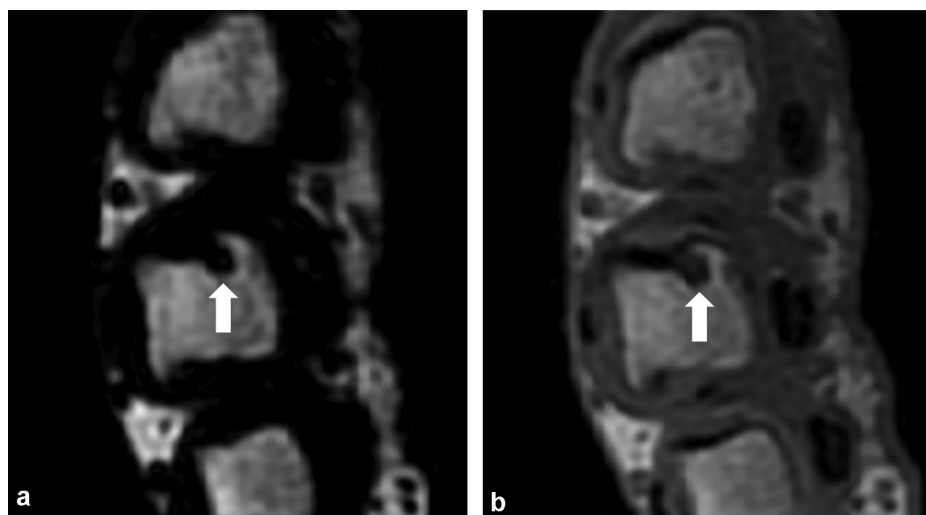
Sixty-year-old man with rheumatoid arthritis. (a) Axial contrast-enhanced three-dimensional gradient recalled echo (GRE) T1-weighted Dixon fat-only image and (b) axial three-dimensional GRE non-Dixon T1-weighted image without contrast material injection show a similar appearance of metacarpal head erosion (arrows).
